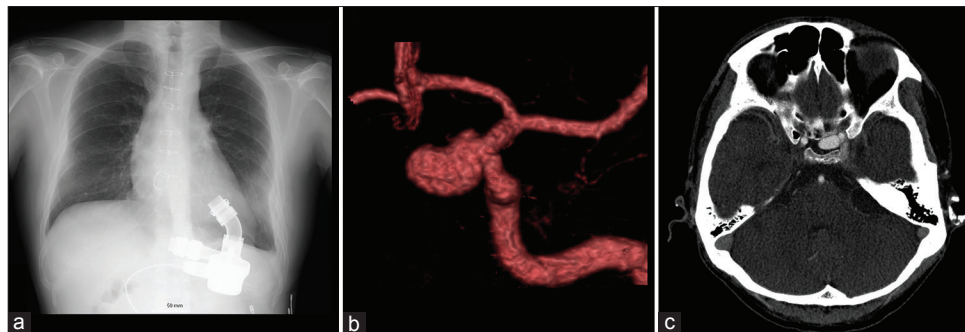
Continuous-flow left ventricular assist device (CF-LVAD) was implanted for fulminant cardiomyopathy (a, chest X-ray). A large aneurysm was incidentally found at the C2 portion of the left internal carotid artery, 13 mm in its size, and had a bilobular shape (b, CTA). The aneurysm was projected medially and situated at the sellar region (c, CTA). CTA: Computed tomography angiography, LVAD: Left ventricular assist device.
